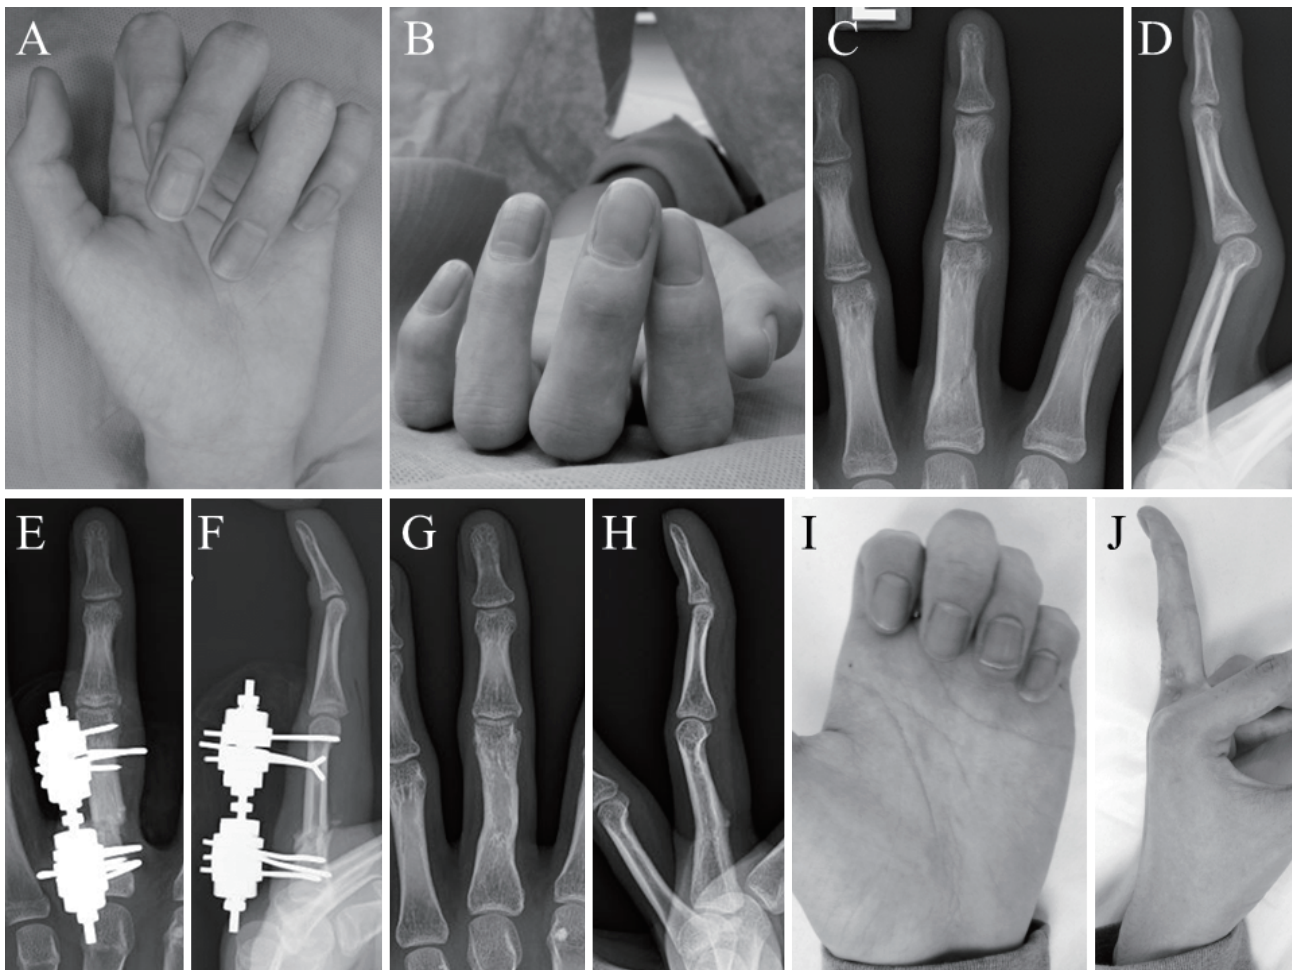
A photograph of a 15-year-old right-handed male patient with posttraumatic malunion of left third proximal phalanx. Preoperative scissoring deformity of the left middle finger from malunion of a proximal phalanx fracture. Scissoring deformity of the left middle finger over the index finger on grasping (A, B). Radiographs revealed malunion with angular and rotational deformity of the left third proximal phalanx at proximal third of the proximal phalanx (C: posteroanterior, D: lateral view). Postoperative radiographs, showing the osteotomy line and oblique insertion of the dedicated pins (E: posteroanterior, F: lateral view). Follow-up radiographs taken 2 months after the correction surgery showed union of the osteotomy. At the latest follow-up, 24 months after surgery, radiographs showed residual deformity (G: posteroanterior, H: lateral view). Photographs of the left hand with fingers in flexion (I) and in extension (J) without restriction of ROM.
